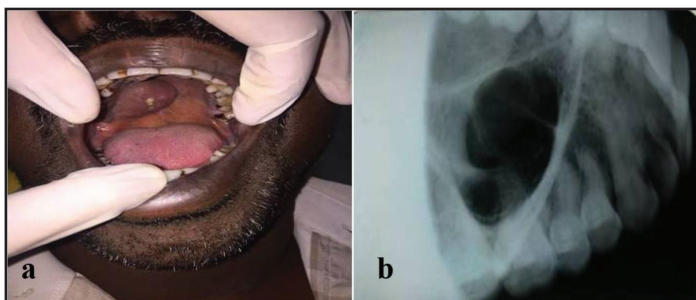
(a) Intraoral palatal swelling as noted on intraoral examination; (b) Occlusal radiograph of the patient.
